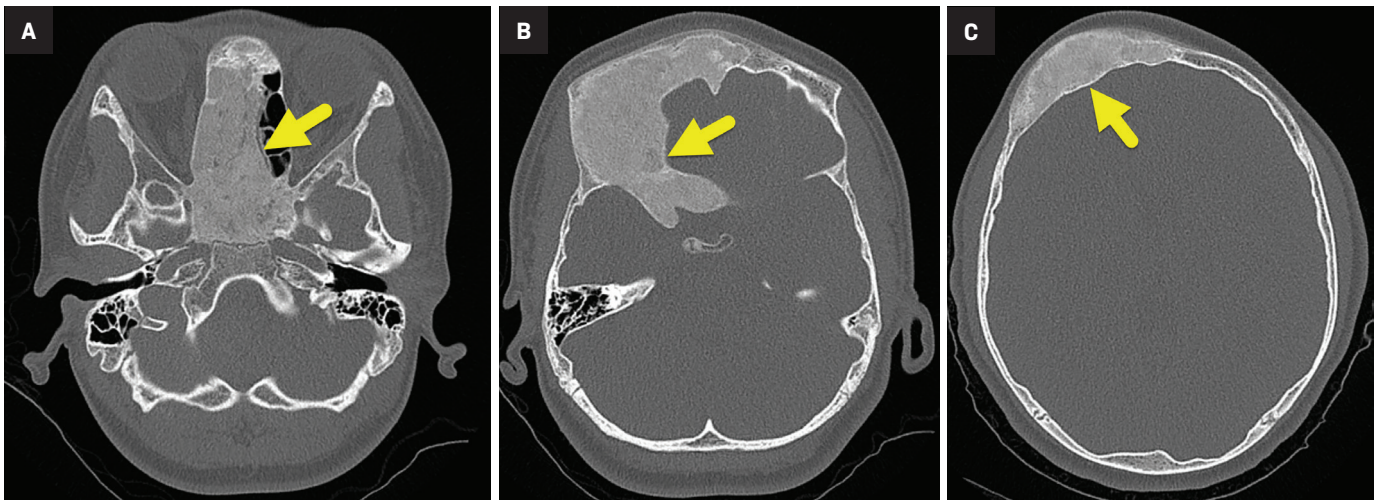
Axial CT images at the level of the ethmoid air cells (A), sphenoid wing (B), and frontal bone (C) demonstrate an expansile sclerotic lesion with a ground-glass matrix extending from the right ethmoid air cells through the right frontal bone.
